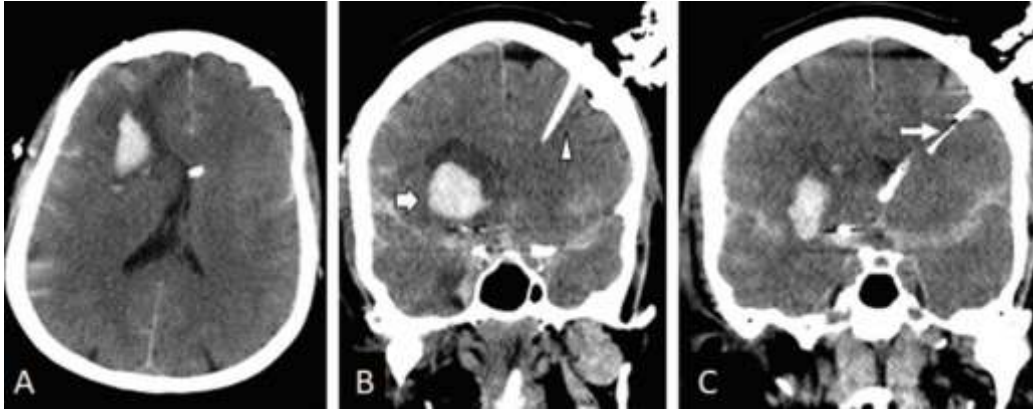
CT images of the head showing diffuse subarachnoid hemorrhage and a frontal parenchymal hematoma with surrounding edema and midline shift. The tip of the EVD is seen in the left lateral ventricle on the axial imaging (Plate A). Coronal sections (Plates B and C) indicate the tip of the Licox probe placed into the normal brain parenchyma (Courtesy of N Badjatia, University of Maryland).
